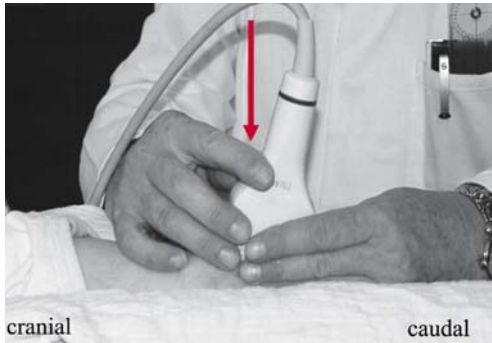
a The probe in this example is tilted cranially, with deflection of the ultrasound beam in the frontal plane. b Sonographic image performed as described in a. The sign of caudo-cranial tilt is disappearance of the osteochondral junction of the proximal femur (1) from the sonographic image. The image can be misleadingly read as pseudo-subluxation
